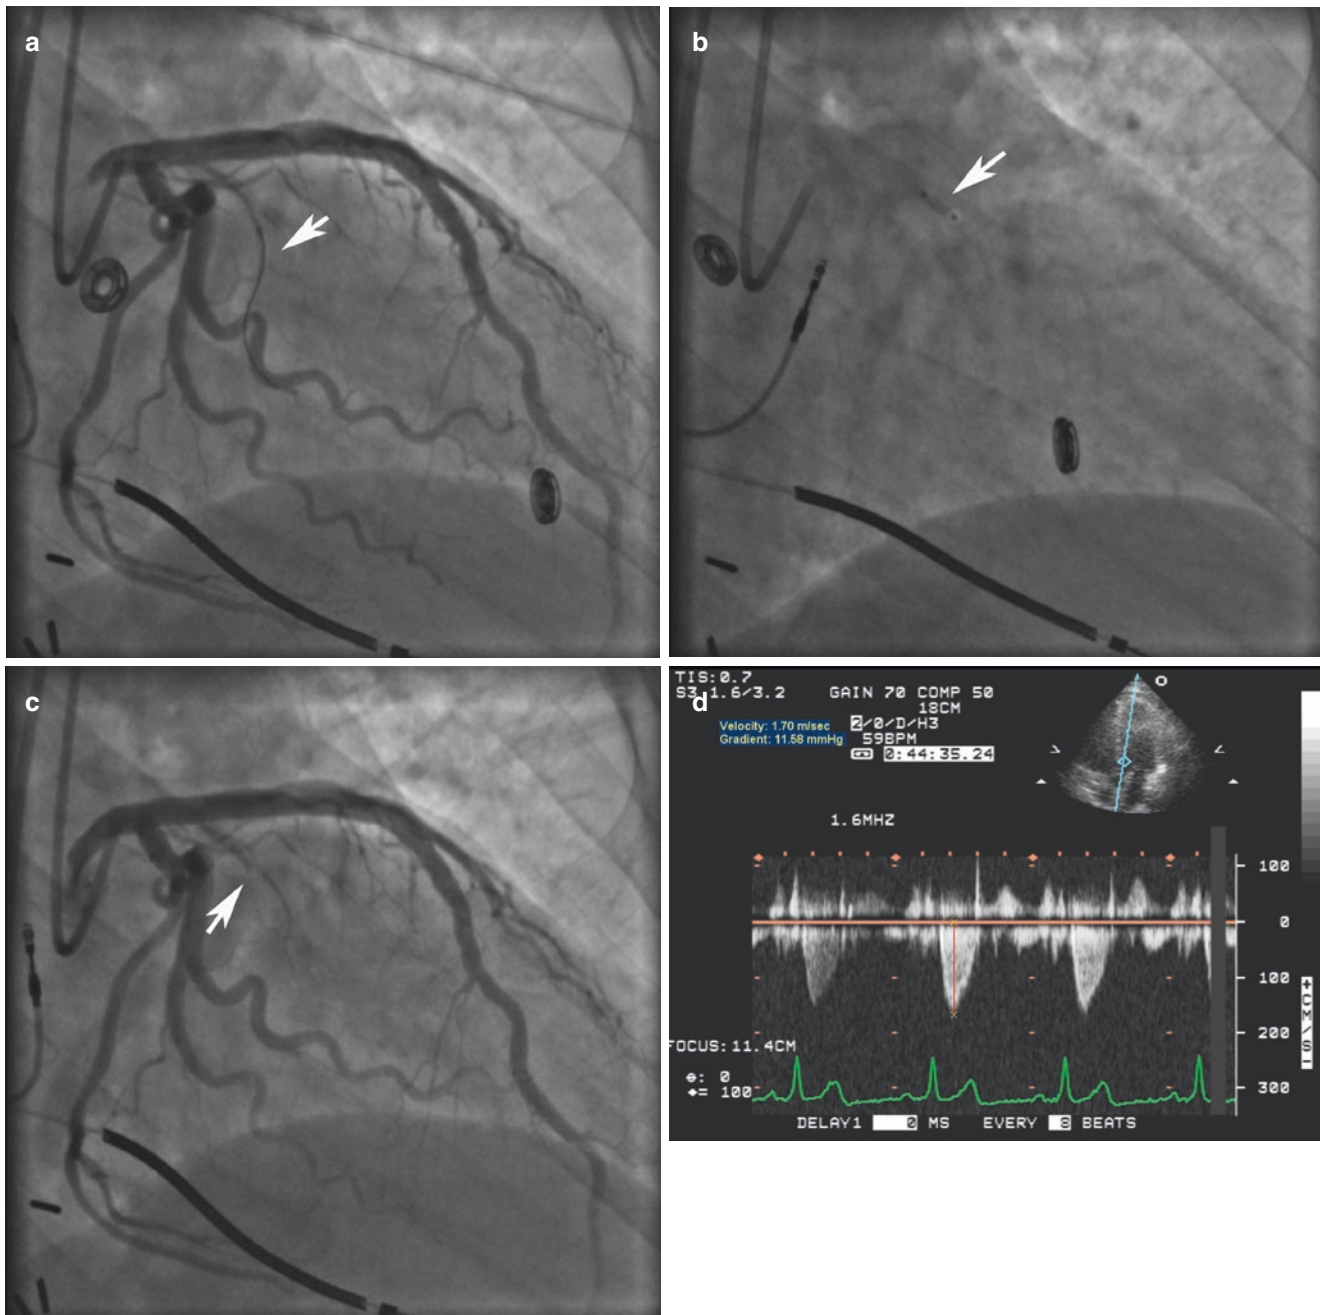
Case 6: Symptoms persisted after initial ablation leading to a TTE study. Spectral Doppler revealed persisted LVOT provokable gradient on the Valsalva maneuver
